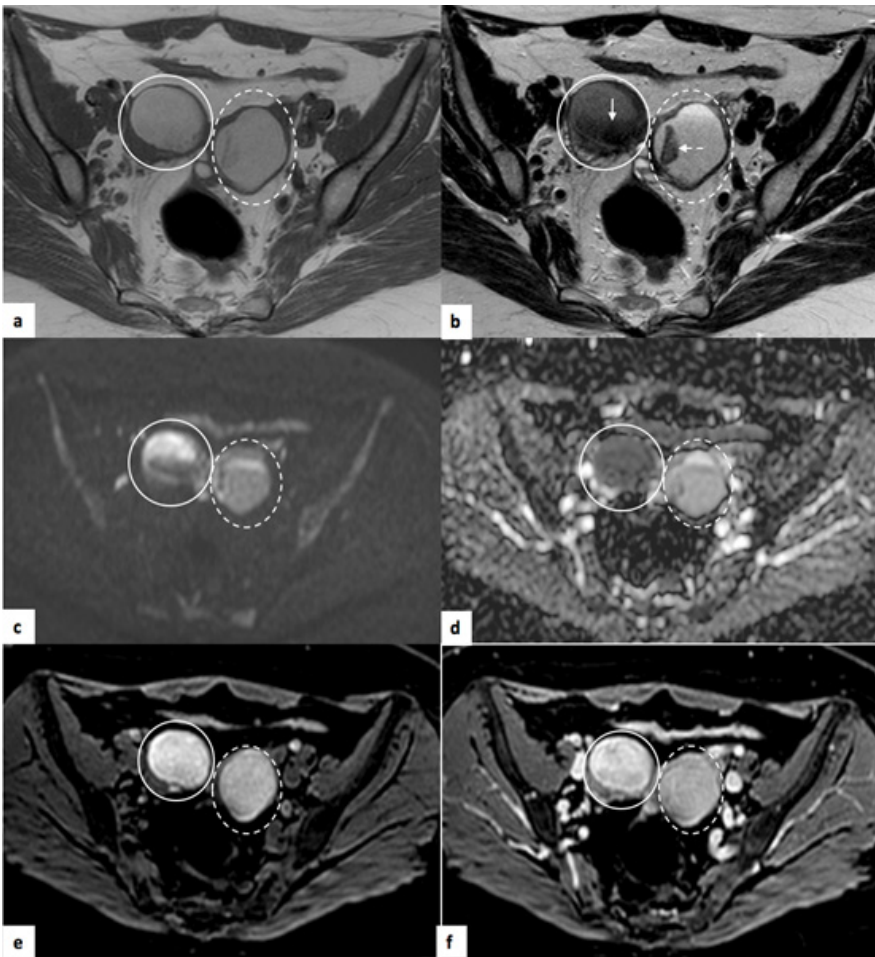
Bilateral endometriomas. Pelvic MRI of a 45-year-old woman. (a) Axial T1WI, where bilateral adnexal lesions with spontaneous high T1 signal are shown. On T2WI (b), the right adnexal lesion (circle) shows heterogeneous loss of signal, with fluid-fluid level (arrow). Left adnexal lesion (dashed circle) presents T2 hypersignal, with focus of T2 hypointensity (T2 dark spot sign) – dashed-line arrow. (c) and (d) correspond to DWI ($b=1000$) and ADC map, respectively, where there is a restricted diffusion, more evident in the right ovarian endometrioma. (e) and (f) T1-weighted images with fat saturation before and after intravenous contrast, respectively, in which the endometriomas maintain an identical appearance, since they present spontaneous T1 high signal, without enhancement after intravenous contrast.
